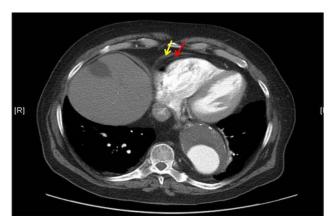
Contrast-enhanced computed tomographic nongated axial image showing the pericardium anterior to the right ventricle (yellow arrow), surrounded by layers of epicardial (red arrow) and pericardial fat.
